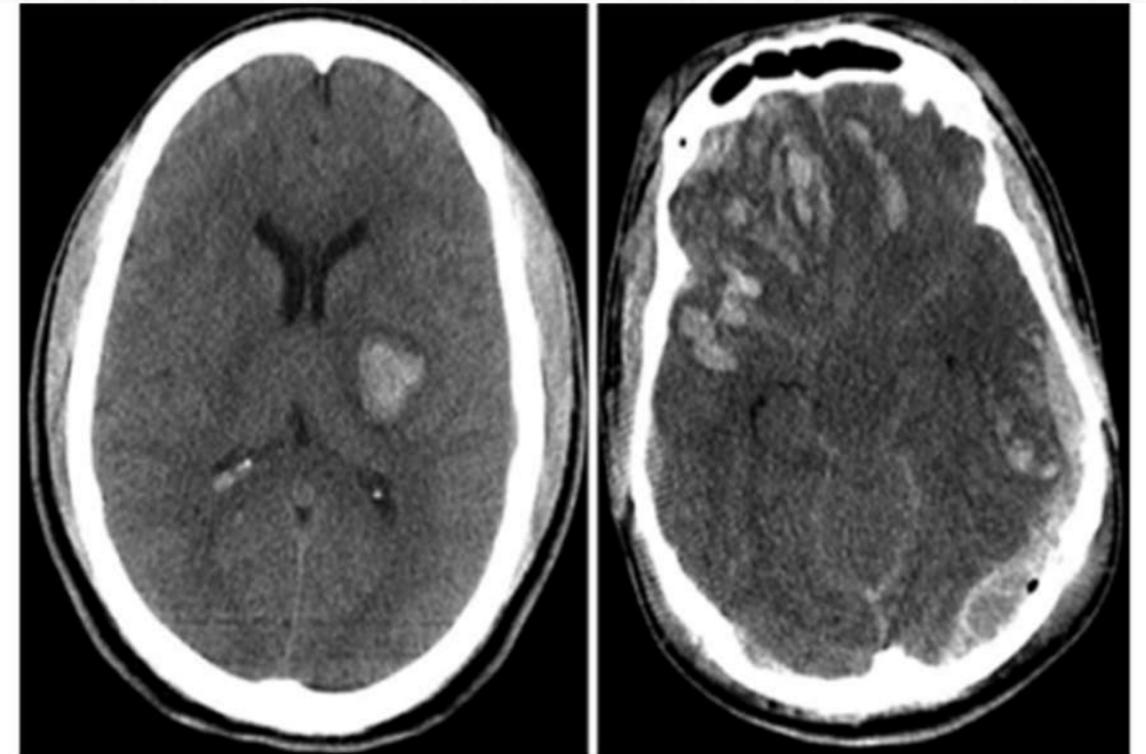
Computed tomography images showing different patterns of contusions.
